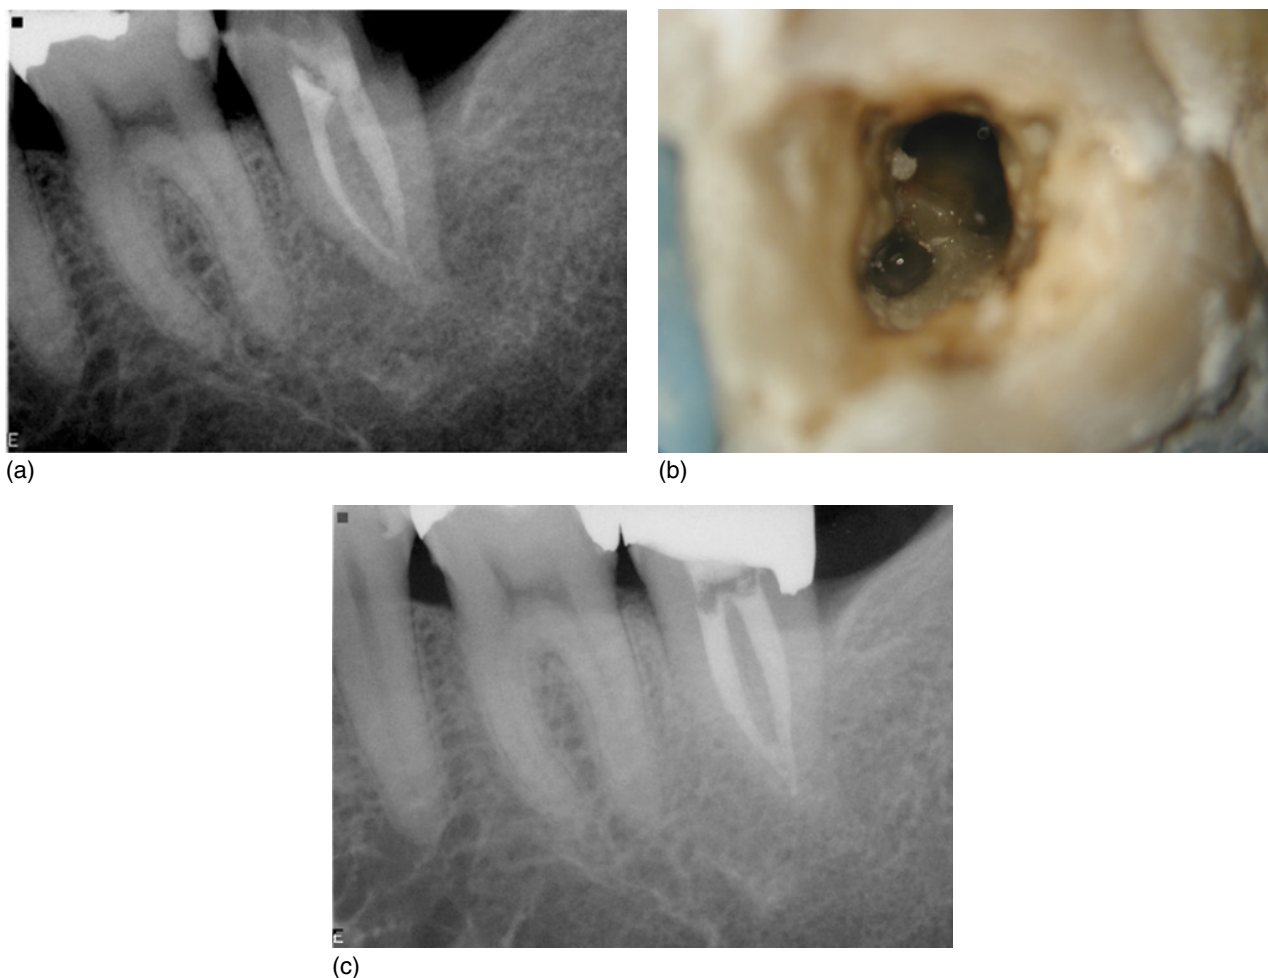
(a) Failed root canal treatment of a C-shaped second mandibular molar. (b) Successful retreatment of a failed root canal treatment of a C-shaped second mandibular molar. (c) One year recall radiograph following retreatment showing complete healing.
